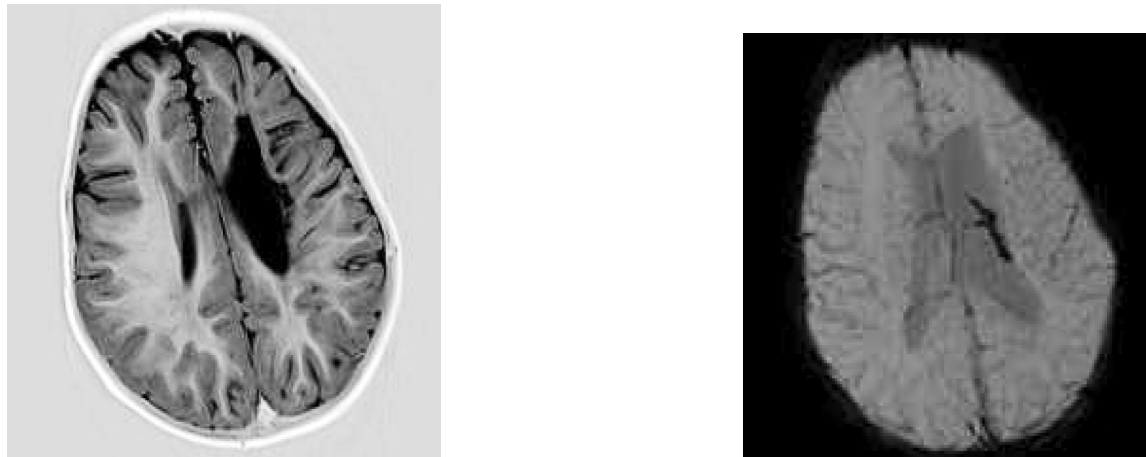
(9a & 9b). MRI brain 2 year old child SWI show chronic hemorrhages in the left ependymal margins, a case of perinatal hypoxia.
